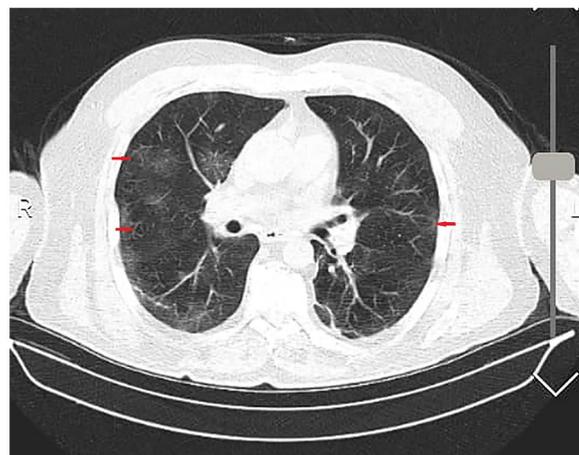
Chest CT showed bilateral lung consolidation with ground-glass opacities suggestive of COVID-19 (Red arrows).
